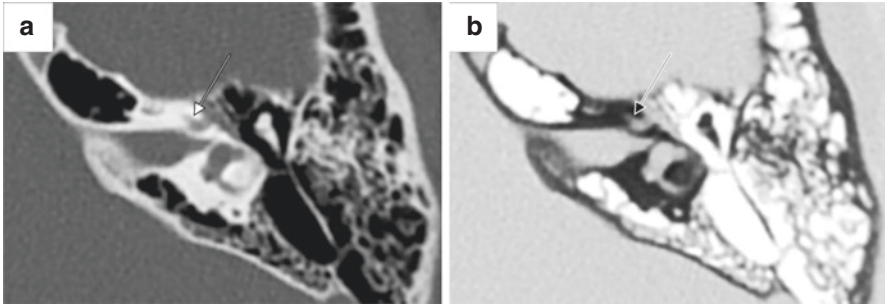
Dehiscence between the labyrinthine segment of the facial nerve and the cochlea (a) axial CT scan and (b) gray-scale inversion image. (Reproduced with permission of *Annals of Otolaryngology, Rhinology & Laryngology* [8])
